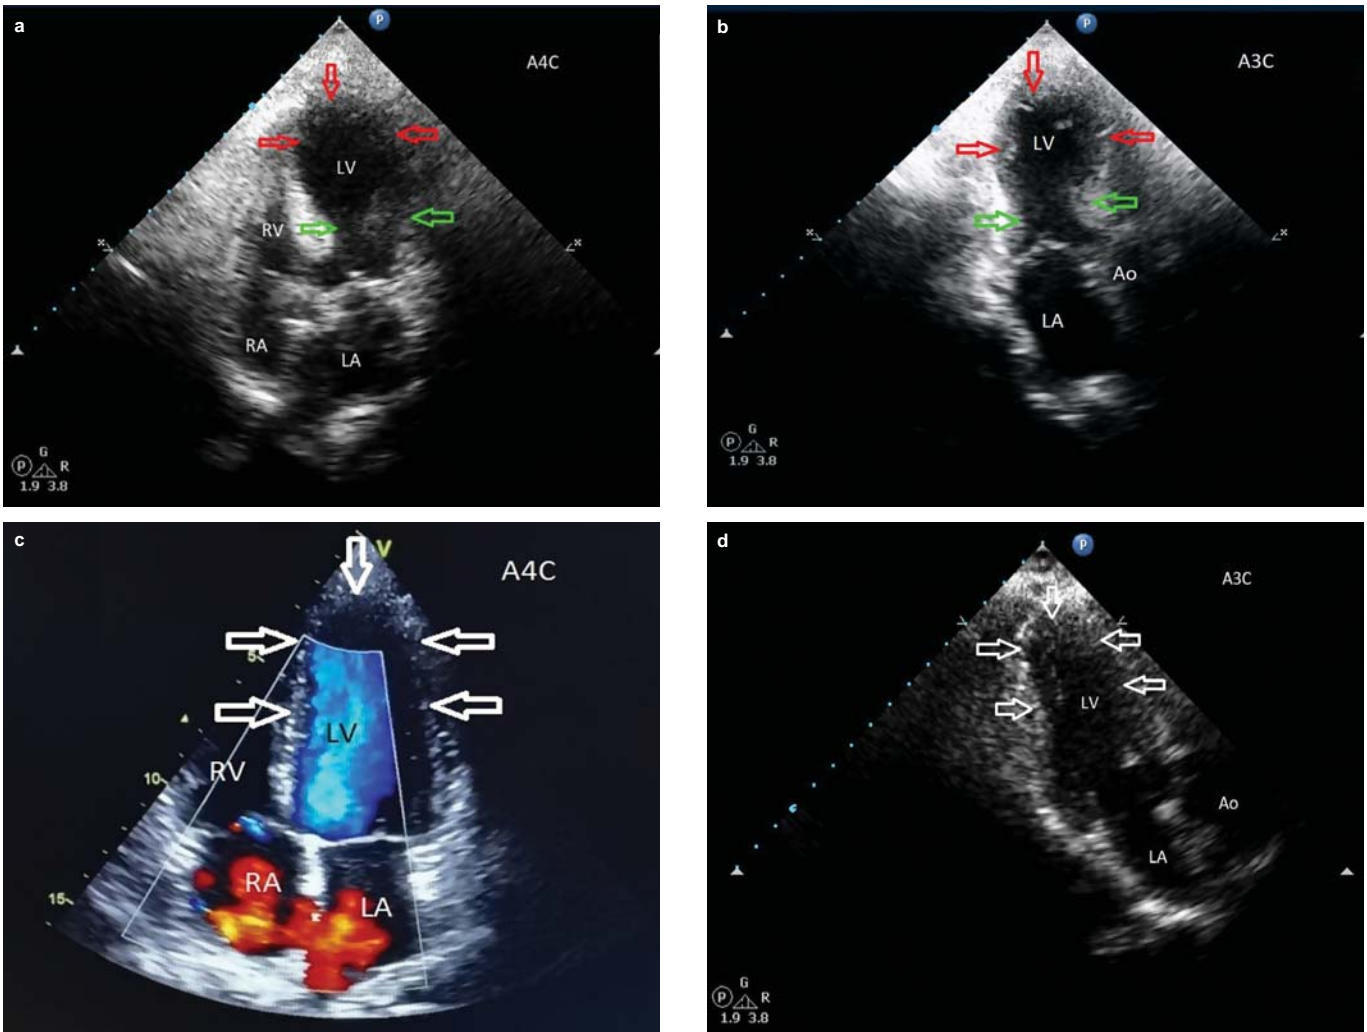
Echocardiogram showing apical ballooning (red arrows), green arrows depicting normal basal segments: (a) apical four-chamber; (b) apical three-chamber views at presentation; echocardiogram during 4 weeks of follow-up showing the disappearance of apical ballooning and normal left ventricular chamber morphology (white arrows); (c) apical four-chamber view with colour Doppler; and (d) apical three-chamber view
